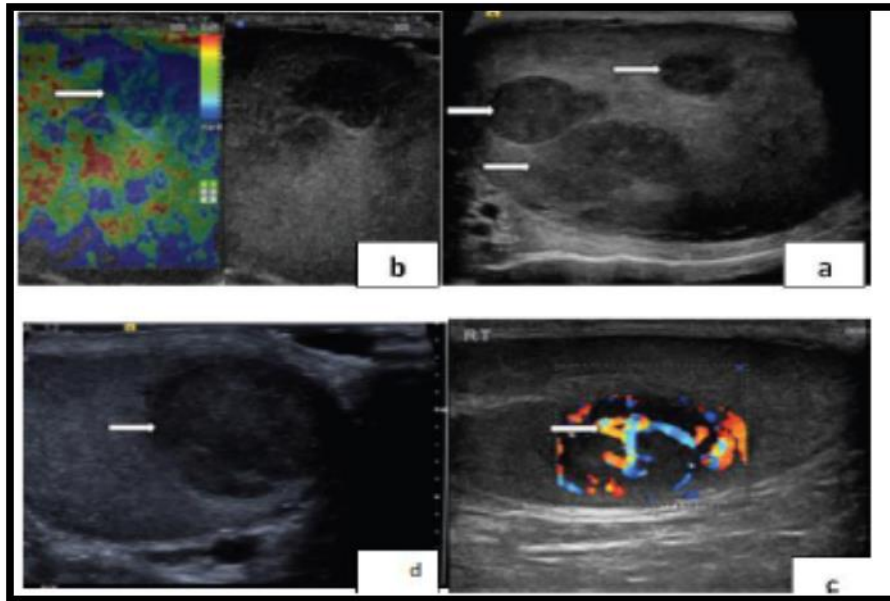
shows the Prostatic metastasis. (a) B-mode ultrasound demonstrates multifocal hypoechoic lesions (arrows). (b) Color Doppler ultrasound demonstrates internal vascularity within the lesions (arrows). (c) The lesions appear “hard” on elastography (blue area arrow). (d) Enhancement is noted within the lesion, confirming internal vascularity and peripheral contrast enhancement (arrow) wall (Ercan et al, 2007).
